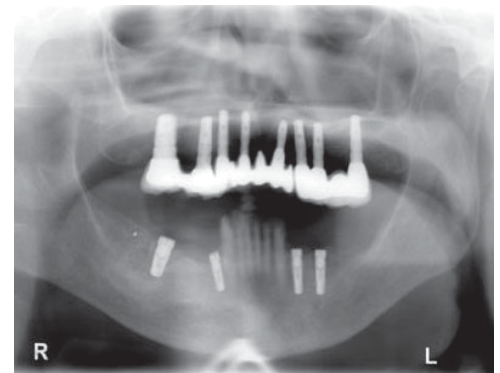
Radiograph of final prosthesis.
